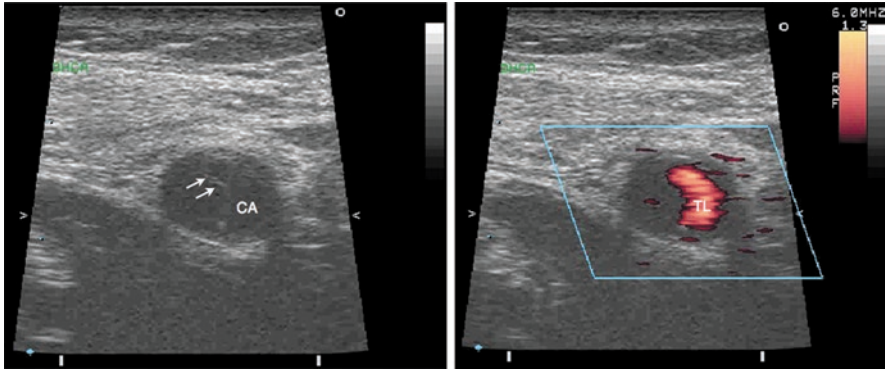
Intraoperative Duplex imaging of the right common carotid artery (CA) in short-axis demonstrating extension of the dissection into the carotid artery in a patient with an acute Stanford type A aortic dissection. Two dimensional ultrasound imaging of the carotid artery (left panel) demonstrates the presence of an intimal flap (arrows) within the lumen of the artery. Color flow imaging (right panel) demonstrated blood flow in the true lumen (TL) with the onset of cardiopulmonary bypass
